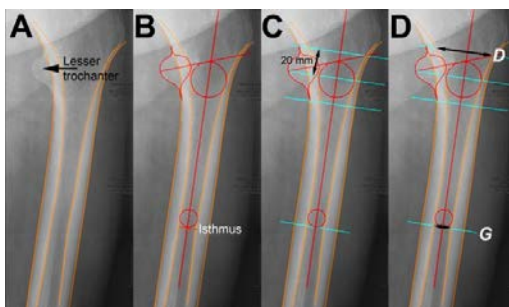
Calculation of canal flare index (CFI) from digital radiographs using an image analysis software. (A) Preoperative digital radiographs of the OA-affected hips were imported to Rhinoceros CAD program. The software was applied to automatically trace the landmarks needed for calculation of CFI. (B) After tracing the cortexes, the most prominent point of the lesser trochanter and the intramedullary femoral isthmus were traced. (C-D) Thereafter the metaphyseal width 20 mm proximal to the most prominent point of the lesser trochanter, D, and the width at the isthmus, G, could be measured. CFI is the ratio of D to G.
